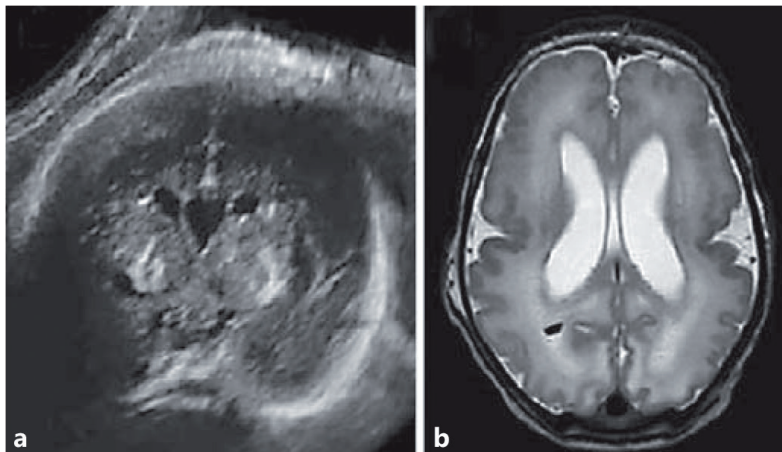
[A] Case 1: fetal US at 32 weeks gestation, coronal plane, showing bilateral LSV; [B] Case 5: MRI, axial T2 weighted sequence, showing ventriculomegaly, increased signal intensity throughout the white, a small hemorrhage in the white matter (right occipital) and bilateral extensive polymicrogyria.
